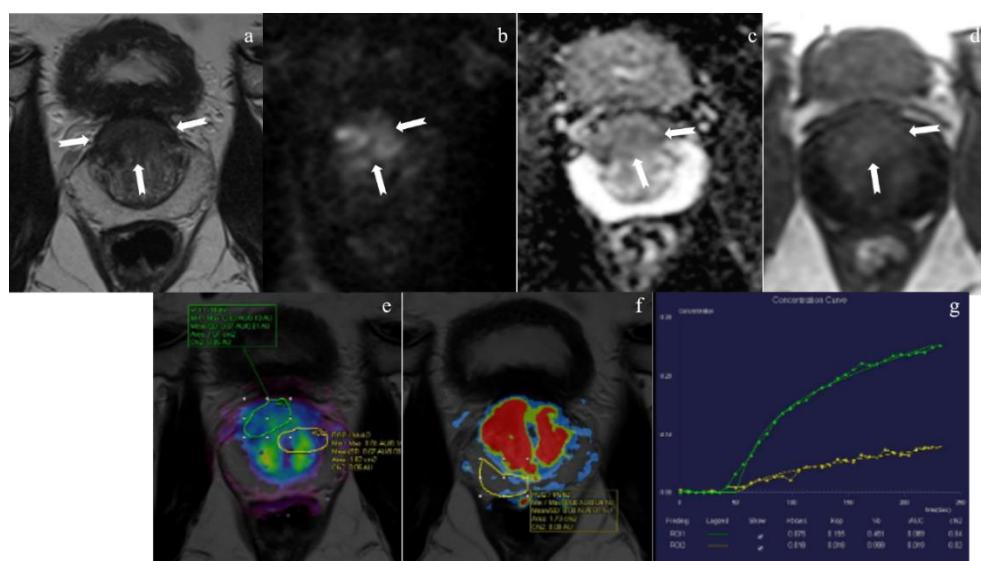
mpMRI images of a 71-year-old patient with PSA 29.81ng/ml and PSAd 0.64 ng/ml/cm³; From a to d, axial T2W, DWI, ADC, DMI, and perfusion maps measured from lesion and normal tissue from e to g, respectively. Reader 1, reader 2, and consensus PI-RADS scores were 5, 5, and 5, respectively (white arrows). TRUS cognitive biopsy result was ISUP 1 in mid anterior TZ. The result of RP was ISUP 3, 45% involvement; Upgrade followed.
